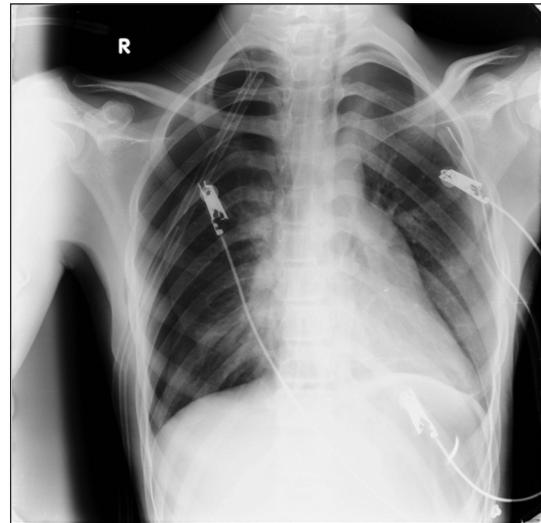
X-Ray graphy of the index patient showing bilateral pneumothorax.
